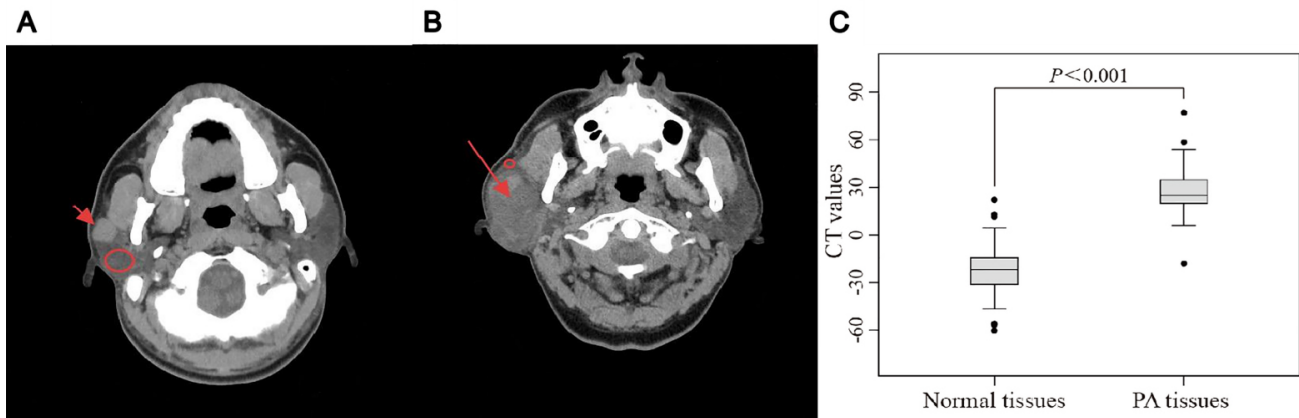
Computed tomography (CT) imaging analysis of the “cell-rich” (A) and “mucus-rich” (B) types of PA in the included population (C). Red arrows indicate the location of the tumor, and red circles indicate the adjacent normal parotid tissue used for CT value comparison and the paired-sample *t*-test of differences in the CT values of PA and normal tissues (C).
